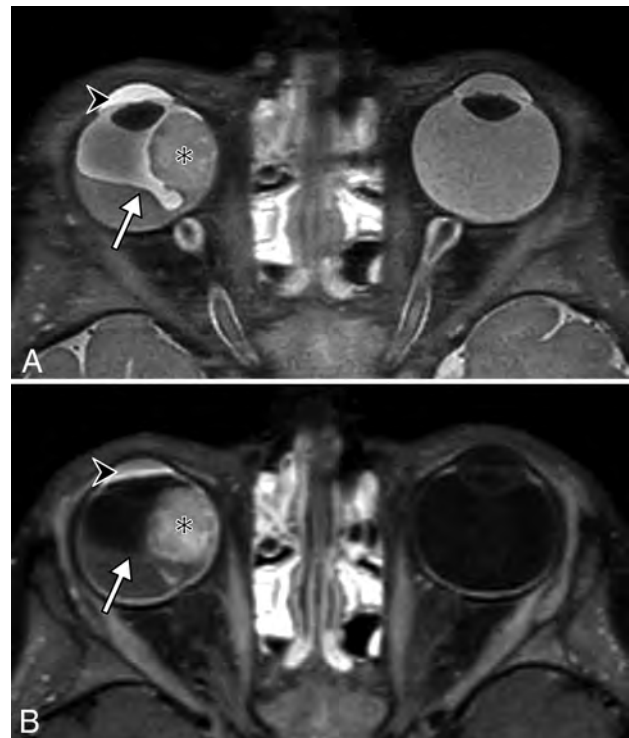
Axial MR imaging T2-weighted sequence (A) demonstrating a V-shaped membrane (arrows) converging on the right optic disc posteriorly (arrowhead), limited by the ora serrata anteriorly. This is the classic appearance of total retinal detachment, confirmed at surgery. There is an underlying subretinal hematoma (asterisk); these are intrinsically T1-hyperintense (B). Note the slightly T1-hyperintense vitreous compared to the contralateral side, consistent with vitreous hemorrhage, initially seen at slit-lamp examination.
